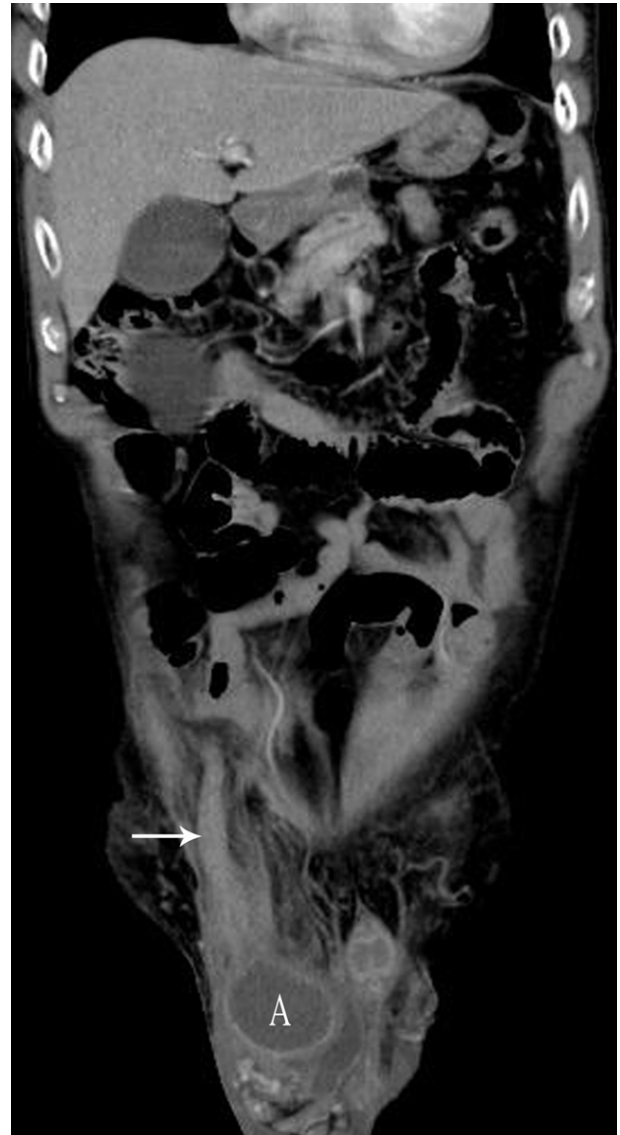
Coronal reformat contrast-enhanced computed tomography image of the inguinal region showing the path of the swelling appendix (arrow) through the inguinal canal and into the right scrotum, along with perforation and abscess formation (denoted by A). The extent of septic changes was confined within the sac. The diagnosis of Amyand’s hernia with localized scrotal abscess was confirmed.
